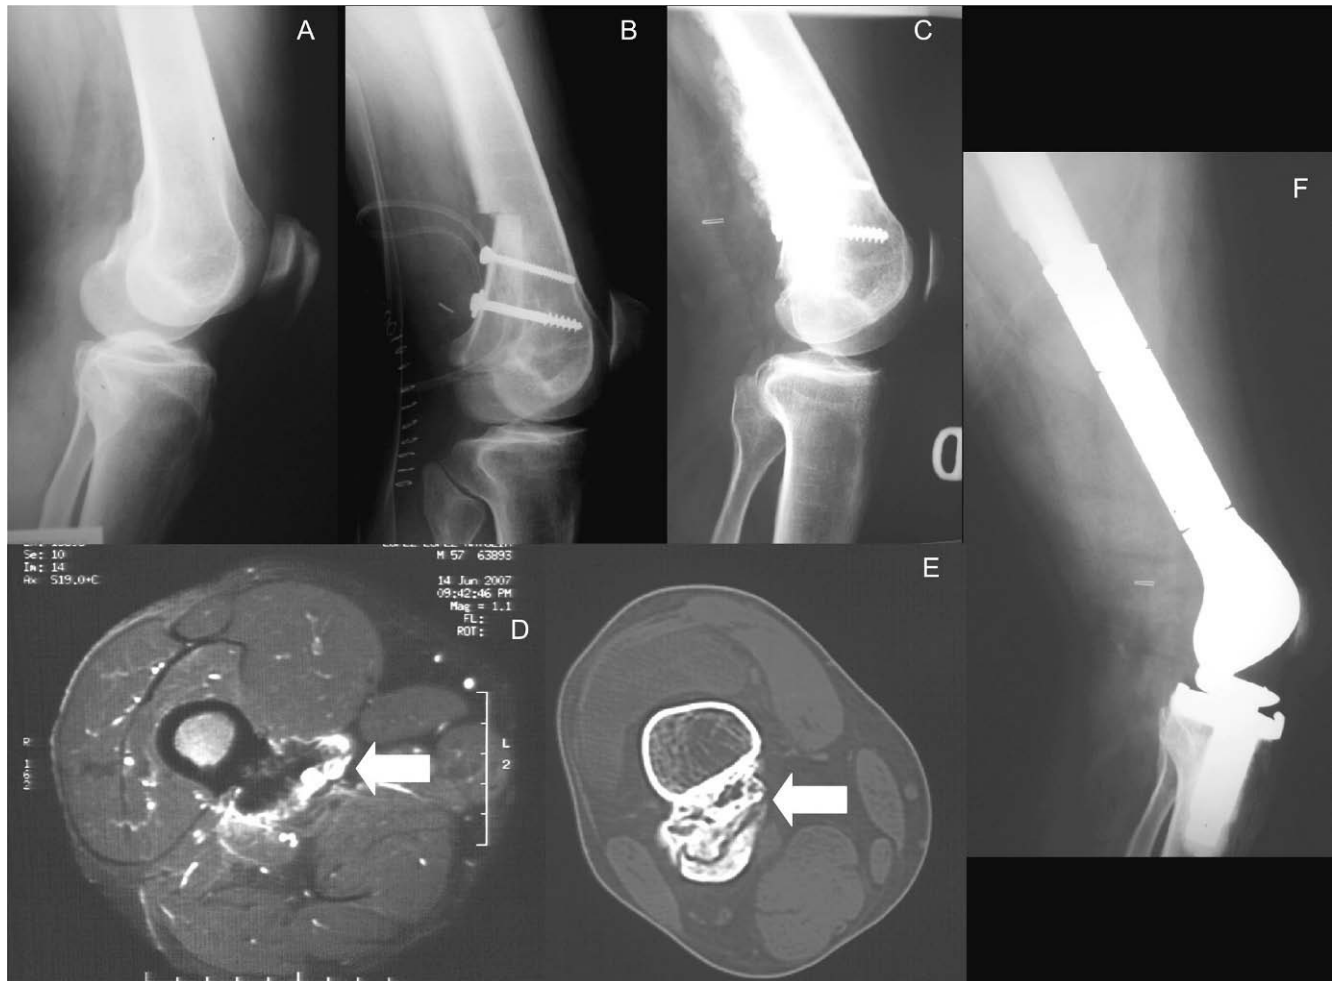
A) Distal femur radiograph of the patient described in Case 3 that shows the lesion initially described as an osteochondroma. B) Follow-up radiograph of the same patient where we resected the parosteal osteosarcoma and performed a reconstruction with structural bone bank allograft. C) Radiograph of the same patient showing recurrence of the parosteal osteosarcoma over the allograft. D) Magnetic resonance view showing the relationship of the femoral vessels with the tumor (arrow). E) Computerized tomography showing tumor growth around the femoral vessels. F) Follow-up radiograph of the tumor resection surgery showing the reconstruction carried out by means of a tumor knee prosthesis.
